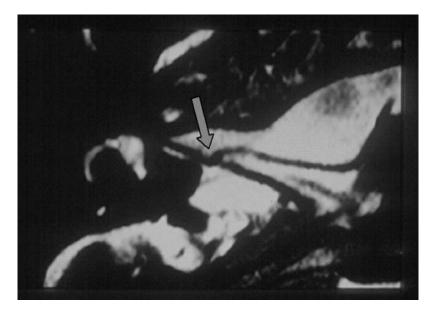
Neurovascular cross-compression of the vestibulocochlear nerve by a loop of the anterior inferior cerebellar artery (*arrow*) in a magnetic resonance image with three-dimensional constructive interference in steady-state sequence.
